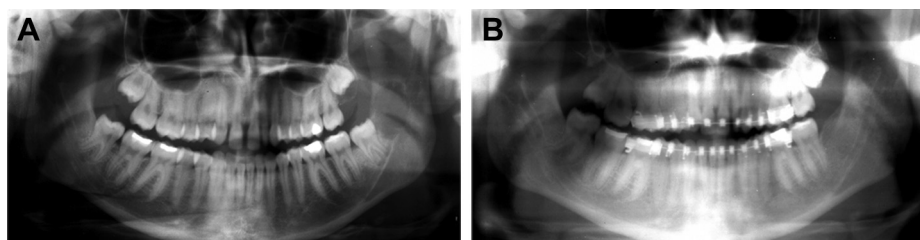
A. Panoramic radiograph revealing a unilocular radiolucent, with scalloped, well-circumscribed margins involving the left ascending ramus of the mandible with relationship to the third molar. B. Panoramic radiograph 2 years post-operative showing complete bone healing.
